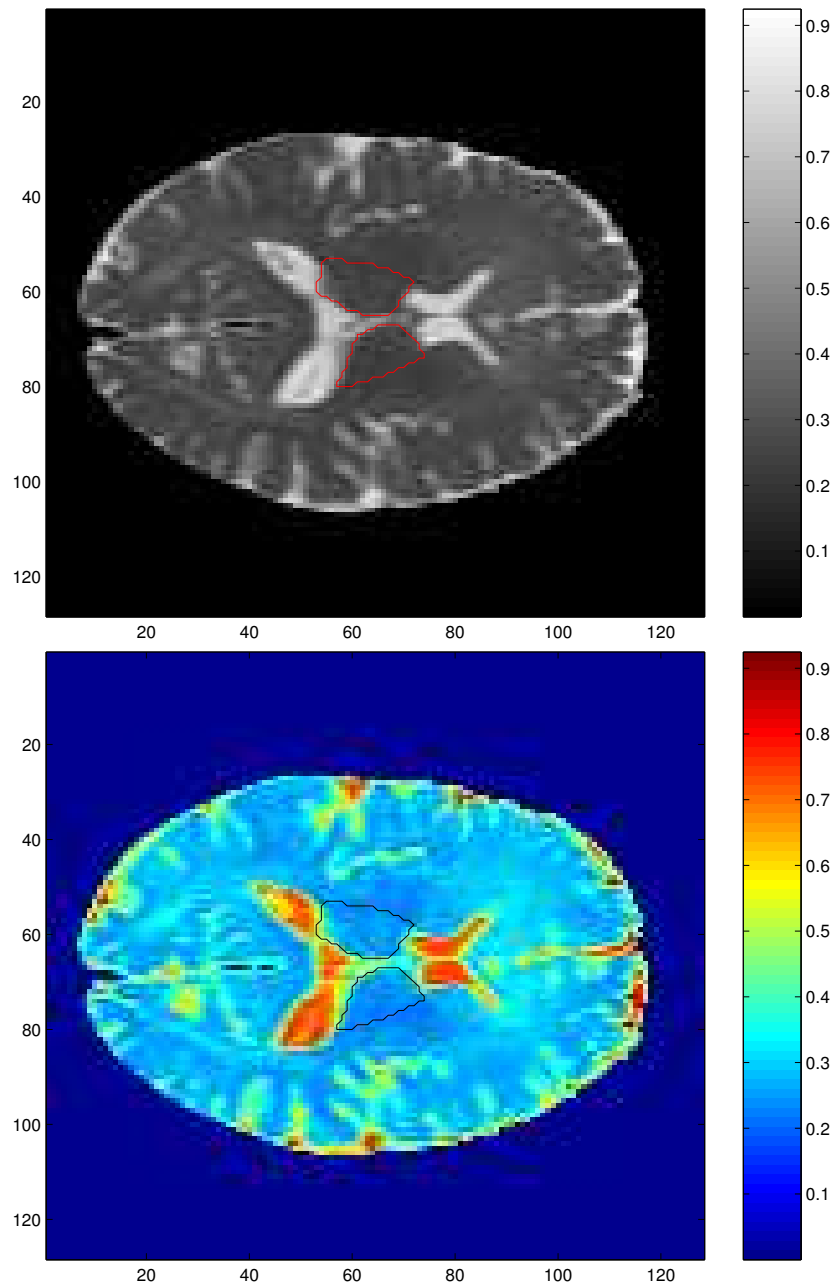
Normalized Mean Diffusivity maps of a DT-MRI, axial slices. Same cut (slice #20) in black and white, and colours. The thalamus is the area inside the red (black and white image) and blue (colour image) contours, in the center of both images.
